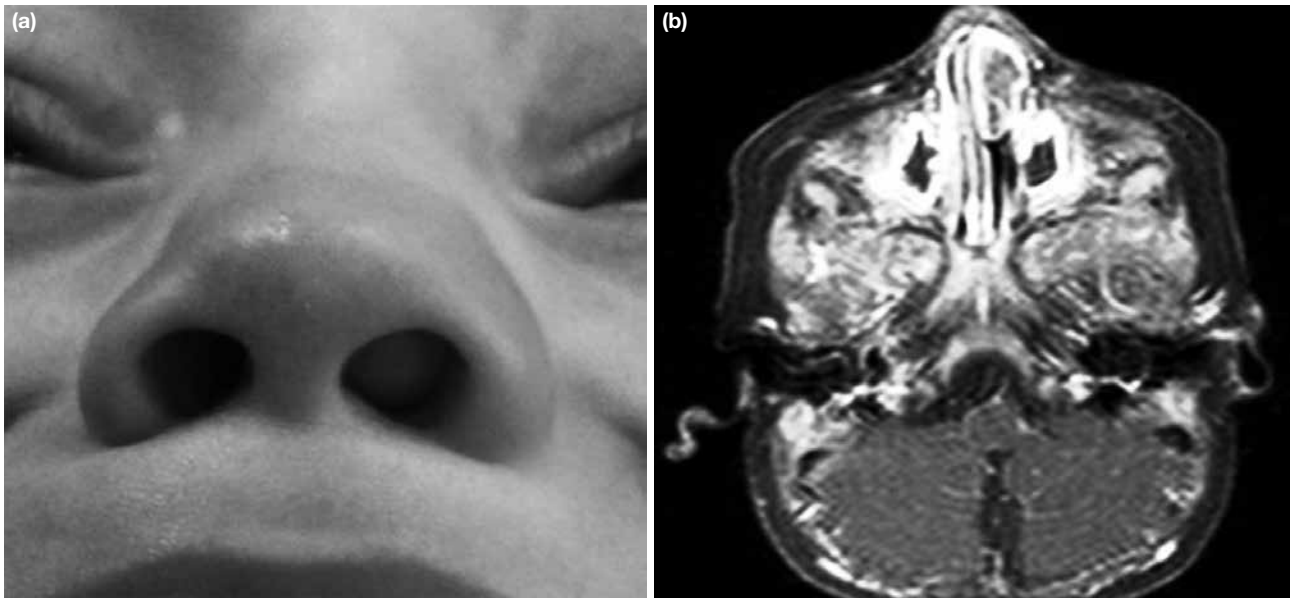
a, b. The mass filling the left nasal cavity (a). MRI of the tumor in axial plan (b).
